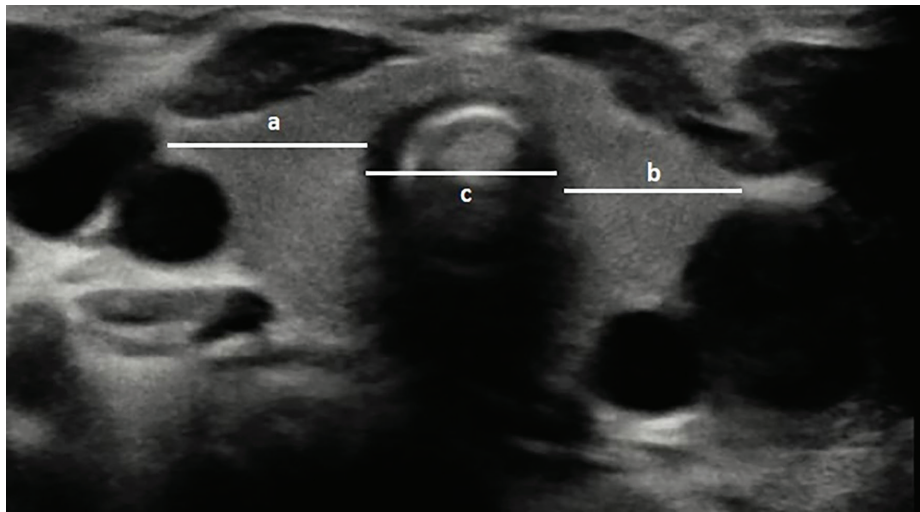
Calculation of the tracheal index on a transverse sonogram of the thyroid [the sum of the maximum width of each thyroid lobe (a + b) divided by the width of the trachea at the level of the thyroid (c) gives the transverse sonogram tracheal index]
